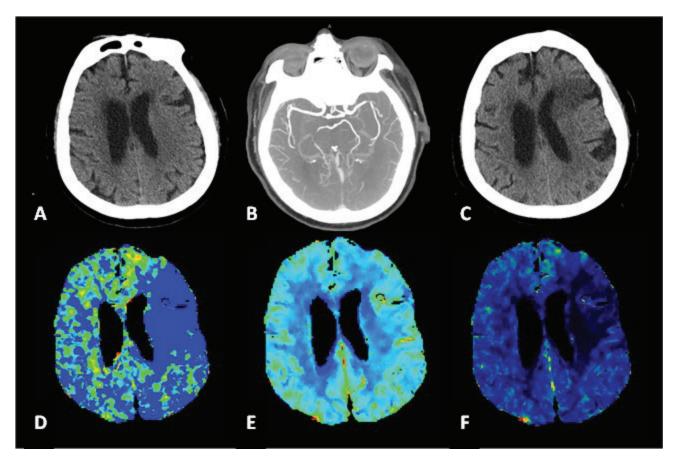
80 year-old woman presented to the ED with sudden onset aphasia, right gaze preference and facial droop. Non-contrast CT (a) showed no evidence of hemorrhage. CTA showed partial occlusion of the distal left MCA (b). She was treated with IV t-PA within 53 minutes of symptom onset. Her repeat head CT 24 hours later showed a partial left anterior MCA infarct and no hemorrhage (c). CT perfusion images consisting of mean transit time [MTT] (d), cerebral blood volume [CBV] (e), and cerebral blood flow [CBF] (f) were consistent with a mismatch between a larger territory at risk on the MTT images compared to the region with decreased CBV. The CBV correlated well with the final area of infarct on CT (c).
